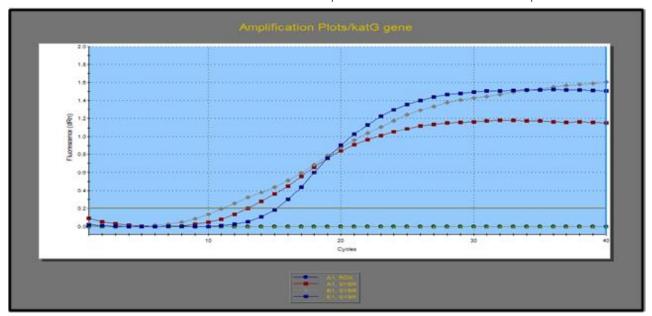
Three sybr green signals levels of master mix real time PCR that indicate to mutant *M. tuberculosis* with *katG* gene from two examinations. (First curve crossed with 17 CT value and the other curves with negative CT value).
